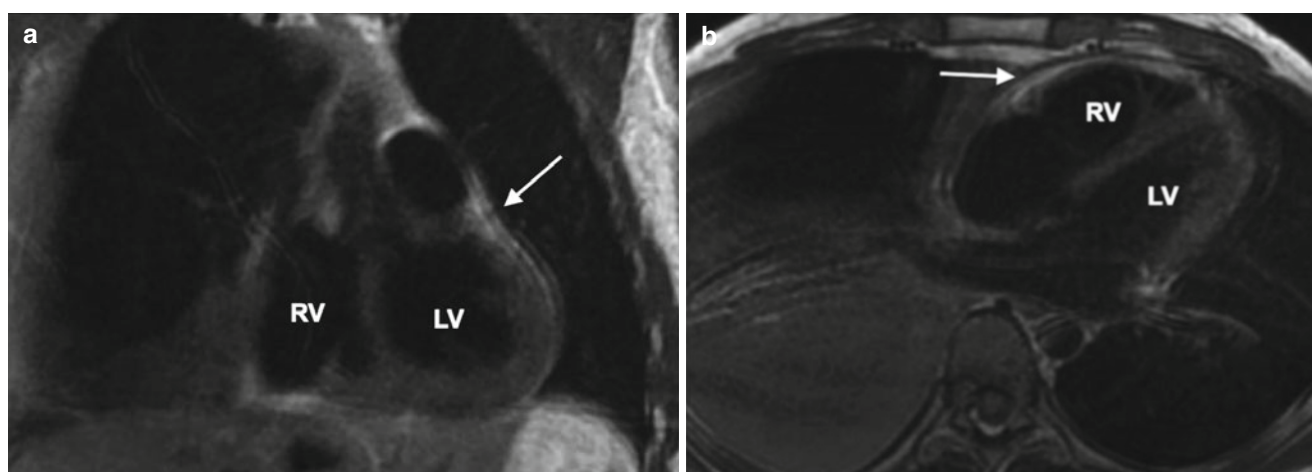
Cardiac MRI demonstrating constrictive pericarditis. (a) Coronal section and (b) transaxial section through the apex of the heart, demonstrating thickening of the pericardium (arrows). RV right ventricle, LV left ventricle
